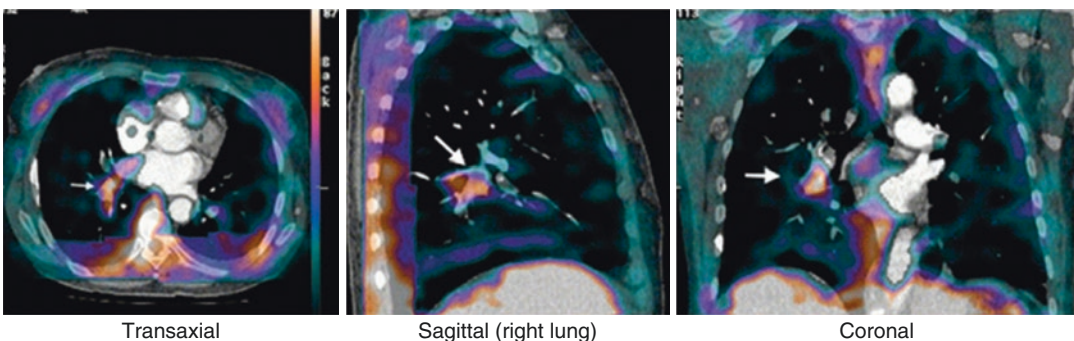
Fused SPECT/CT images of acute PE after administration of ^{99m}Tc -labelled anti-d-dimer antibody fragments. The thrombus (*arrowed*) corresponds to an
